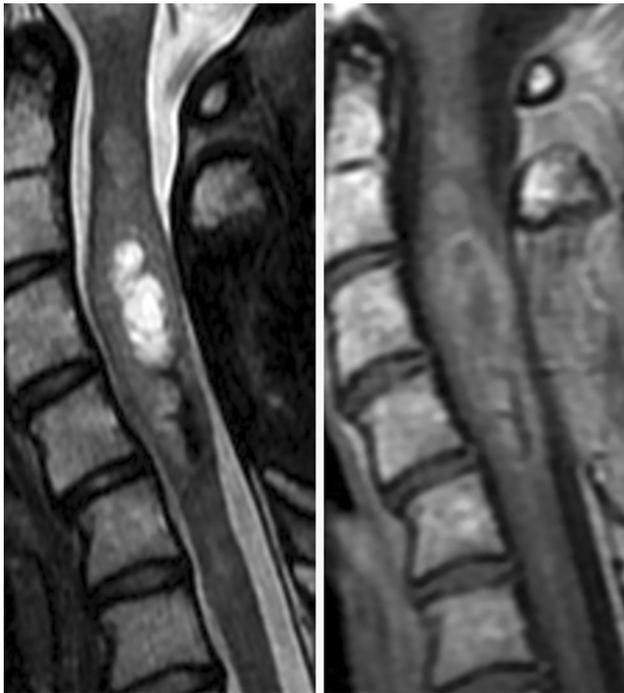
MR imaging of a typical cervical spinal cord ependymoma. The majority of the lesion is hyperintense on T2 (*left*) and demonstrates distinct borders and local cord expansion. T1 with contrast (*right*) shows peripheral enhancement with non-enhancing hypo-intense portions that may represent cystic change, necrosis, or hemorrhage
